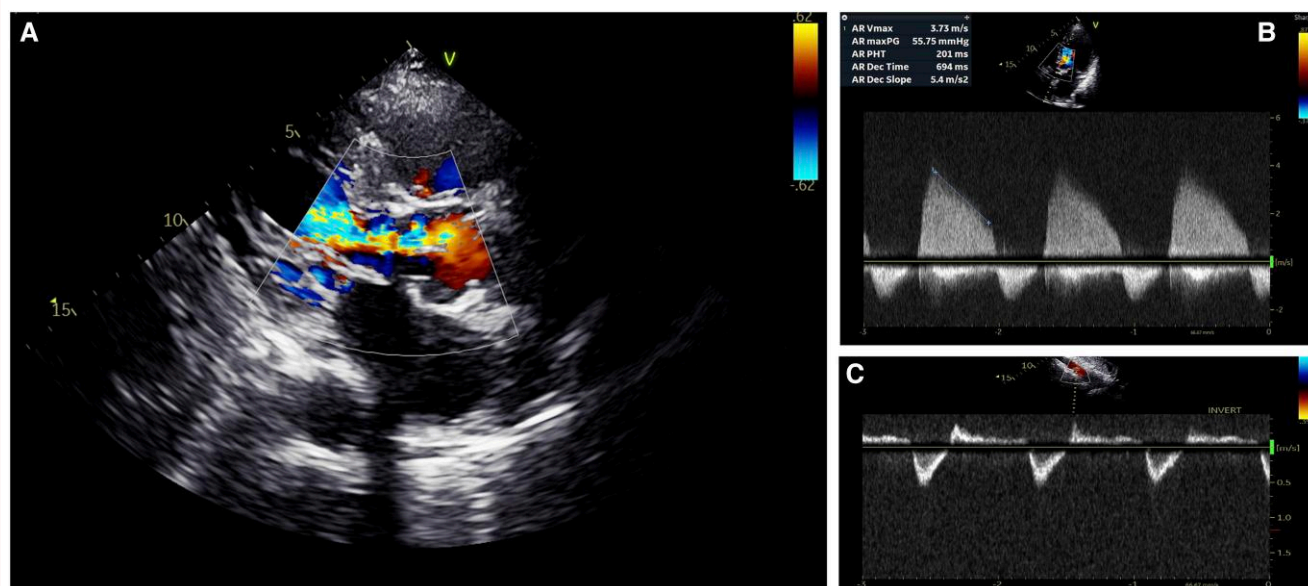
Transthoracic echocardiography showing severe intravalvular aortic regurgitation (A) with Doppler aortic pressure half time of 201 ms (B) and holodiastolic reverse flow in descending aorta (C).
